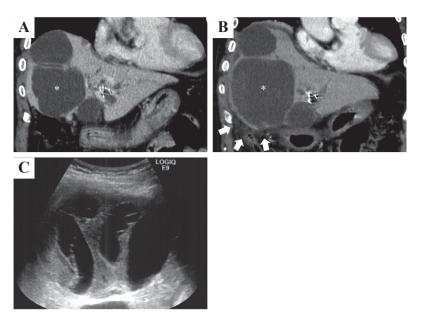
Computed tomography and ultrasonography images at diagnosis of hepatic cyst infection. A: Contrastenhanced computed tomography (CECT) image one month prior to the onset of hepatic cyst infection. B: CECT image at diagnosis of hepatic cyst infection. The diameter of the hepatic cyst marked with an asterisk had increased from 10 cm to 12 cm. The area of increased density of mesenteric adipose tissue is indicated by arrows. C: Ultrasonography image showing mixed hypoechoic and hyperechoic areas within the cyst and recognition of septum-like structures.
